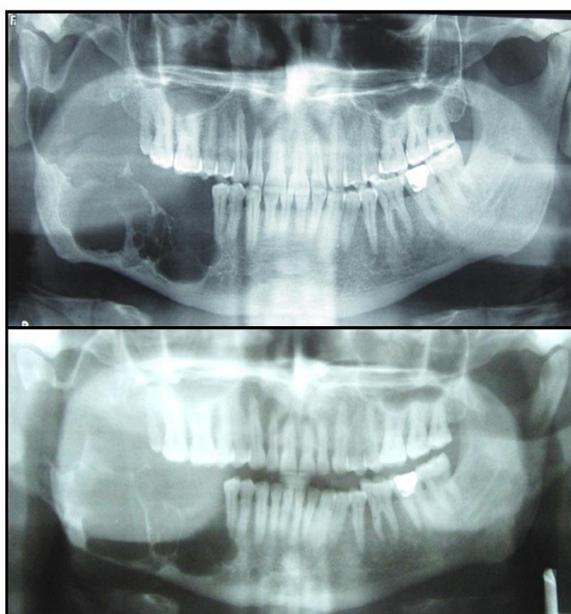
Panoramic radiograph in the year 2013
